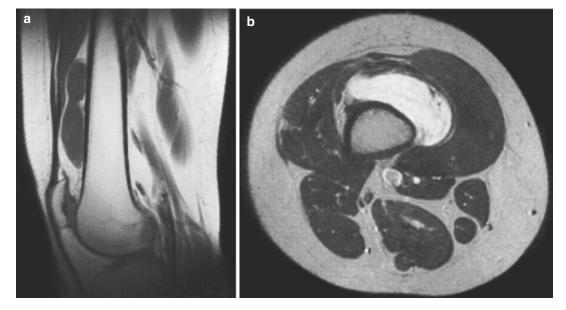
(a, b) Lipoblastoma of the thigh in a 30-yearold woman. (a) Sagittal SE T1-weighted MR image. (b) Axial SE T2-weighted MR image. Dumbbell-shaped lesion located between the distal femoral diaphysis and the vastus intermedius muscle. The lesion is isointense to
